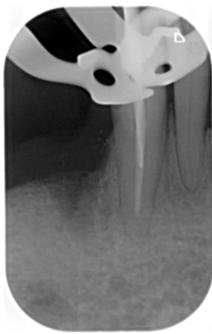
X-ray image for measurement with Rebilda Post drill (diameter 2mm).
